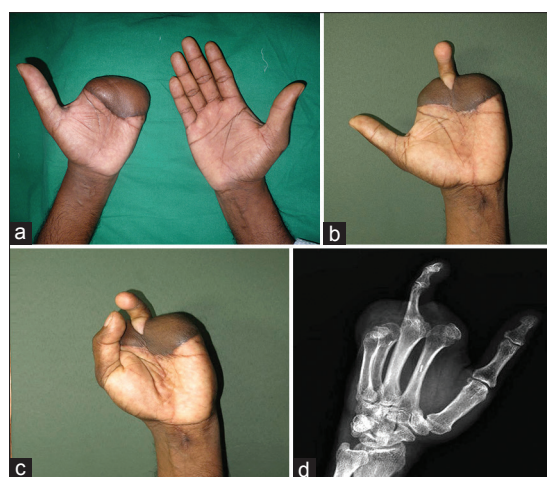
Patient 4, type 1B metacarpal hand. (a) Both hands, prior to toe transfer showing well-settled groin flap covering stump of left hand. (b) Left hand following 2nd toe transfer to the middle finger position, showing maximum span and (c) attempting full opposition. (d) Oblique radiograph 15 months following toe transfer showing bony union
